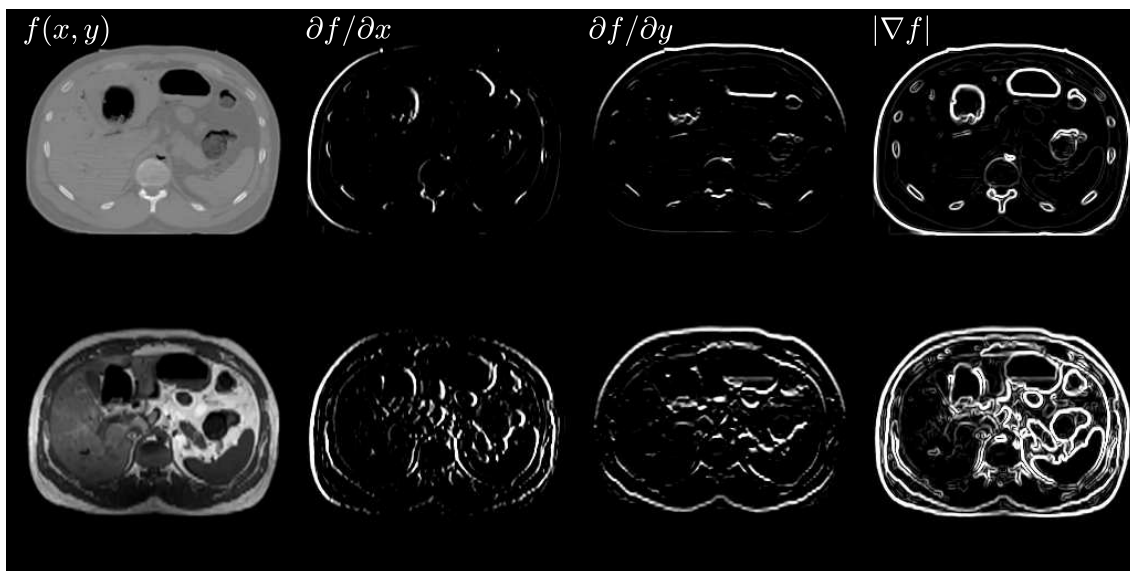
Gradient transform of an abdomen image with CT on top row and MRI on bottom row. From left to right: original image, gradient in x direction, gradient in y direction, and gradient norm.
